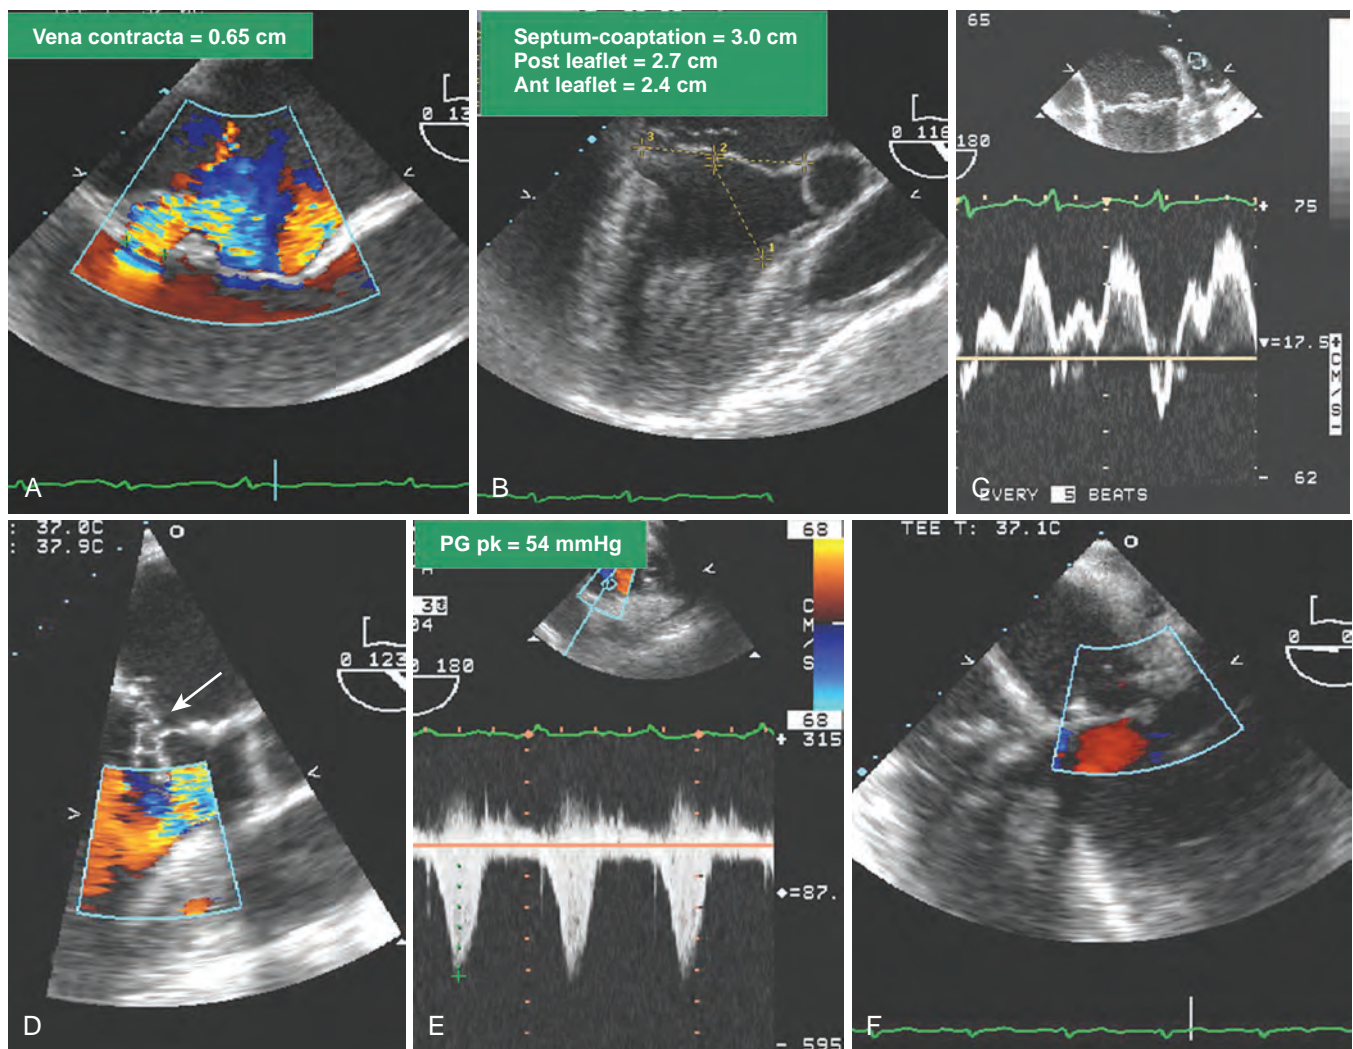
Complex mitral valve (MV) replacement or repair revision. A 58-year-old woman with severe mitral regurgitation (MR) and a history of congestive heart failure, pulmonary edema, and hypertension was scheduled for surgical repair of mitral insufficiency. (A) The prebypass transesophageal echocardiogram characterized the MV as having severe MR with mildly thickened, myxomatous leaflets and several ruptured chordae tendineae. The markedly dilated annulus was consistent with the chronic disease process. Prolapse of the posterior leaflet caused the MR jet to override the anterior leaflet. (B) Although the distance from the septum to the coaptation point of the MV was greater than the value cited by Maslow as predictive of postbypass systolic anterior motion, the ratio of the length of the anterior (Ant) and posterior (Post) leaflets (0.89) suggested a risk for left ventricular (LV) outflow obstruction.³⁹ The midesophageal long-axis view demonstrates several ruptured chordae that resulted in MR having a vena contracta of 0.65 cm. (C) Blunting of the systolic component of pulmonary vein blood flow velocity corroborated the diagnosis of significant MR. The surgeon performed a quadrangular resection of the posterior leaflet and secured the annulus with a no. 30 Physio ring. (D) Postbypass imaging of the midesophageal long-axis view demonstrated a coaptation defect, designated by the arrow, and nonlaminar flow in the LV outflow tract. Shift of the coaptation point medially created laxity of the redundant chordae that were drawn into the outflow tract by systolic LV ejection. (E) The outflow tract obstruction was characterized by peak pressure gradient (PG pk) of 54 mm Hg as determined by continuous-wave Doppler through the outflow tract by using the transgastric long-axis view. Neither the MR nor the outflow tract obstruction was effectively addressed by volume loading and decreasing the inotropic support. Circulatory bypass was reinstituted, and the surgeon revised the previous repair by further resecting the posterior leaflet and enlarging the annular ring to a no. 34. (F) The patient was successfully separated from bypass by using minimal support and had resolution of LV outflow tract obstruction, return of normal hemodynamics, and reduction of MR to trace severity (F).
